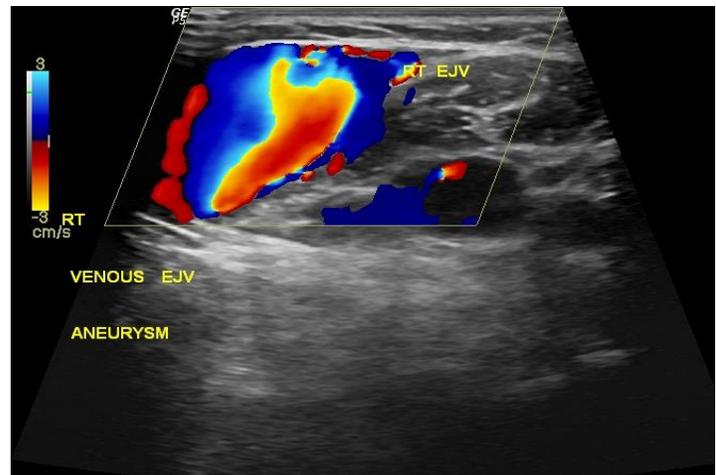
Aliasing Flow on Doppler Examination.
